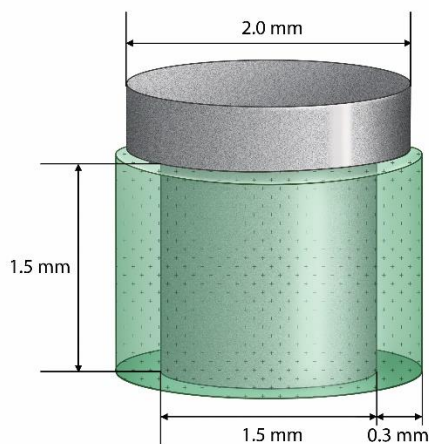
Volume of interest (VOI) for microcomputed tomographic analyses. Green color indicates the VOI.
